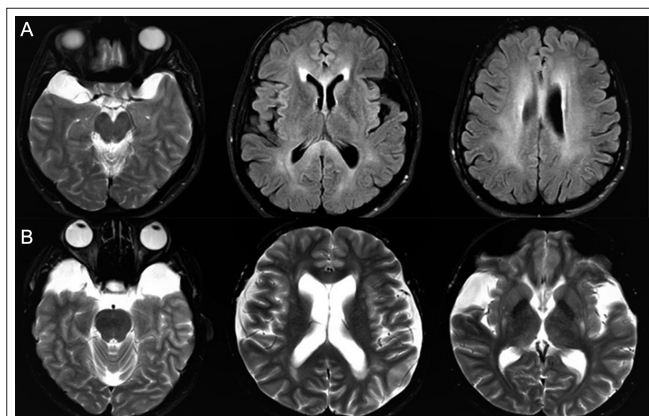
Brain MRI findings of Mother 16 and Mother 17. (A) Brain MRI of Mother 16 revealed subcortical enlargement in the frontal part of both cerebral hemispheres and symmetrical hyperintensities in the subcortical area, periventricular region, and corpus callosum. (B) Brain MRI of Mother 17 revealed bilateral opercular atrophy, subcortical and periventricular white matter involvement, and symmetrical hyperintensities in the putamen. MRI, magnetic resonance imaging.
